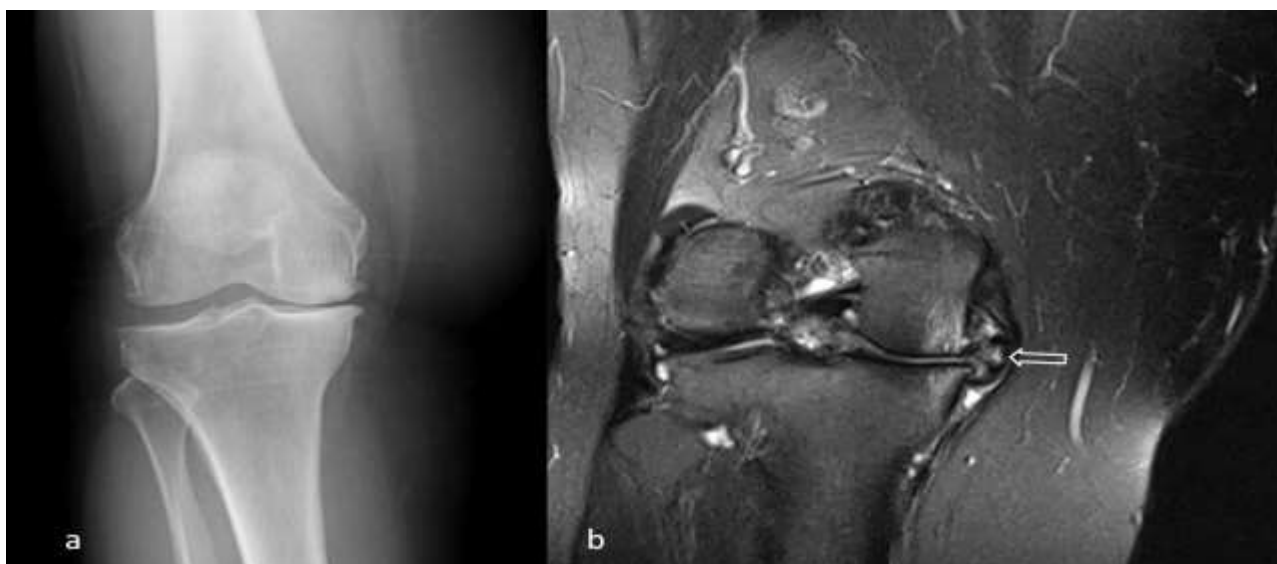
Anteroposterior radiograph of the right knee of a 54-year-old woman with knee pain shows Kellgren Lawrence grade 3 changes (a). A displaced medial meniscus tear (open arrow) is seen on the coronal T2 weighted magnetic resonance image of the same patient (b).
